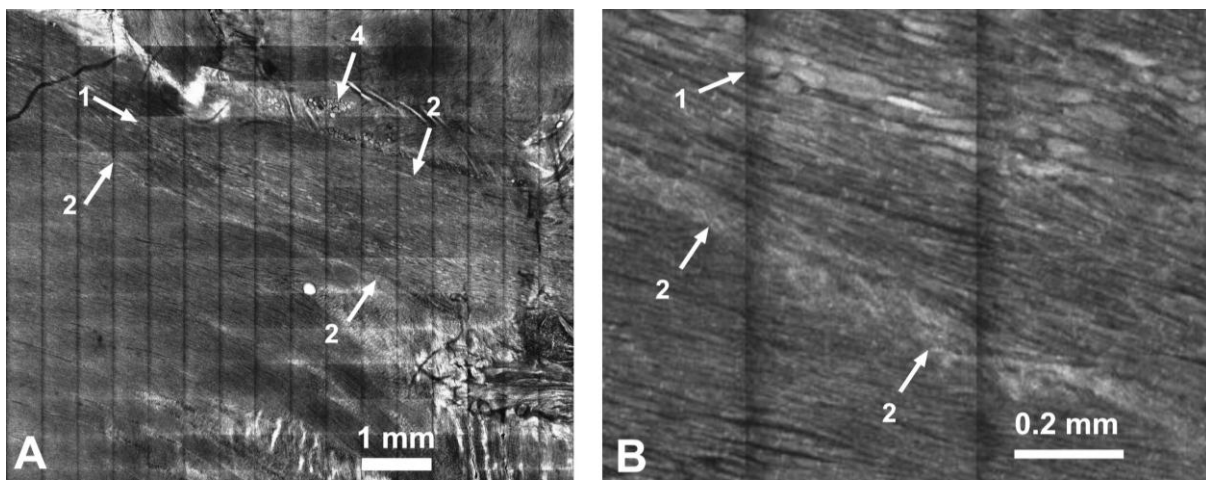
Reflectance images of the heart tissue at a depth of $55 \mu\text{m}$. A – strictly confined right bundle branch of His. B – the boundary between the branch and ordinary MC. Arrow No.1 shows Purkinje cells that are situated like fibers and create a bundle-like structure with the surrounding myocytes. Arrow No.2 marks the fibrous CT that separates the bundle from the ordinary MC. Arrow No.4 marks round lipocytes.
